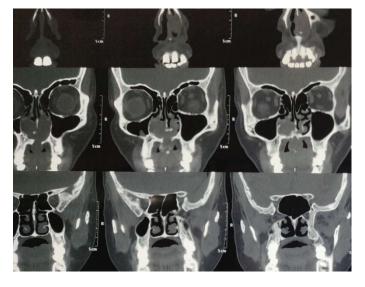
CT scan lesion is extensive with Nasopalatine mass
